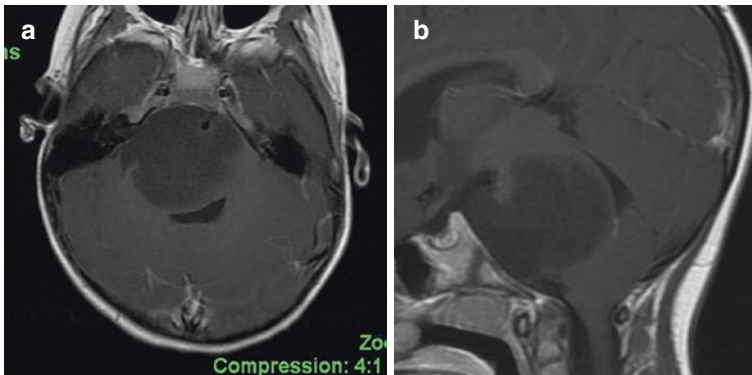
(a Axial, b sagittal) A typical DIPG in a 4½-year-old girl with a 1-week history of facial asymmetry. Note diffuse enlargement of the pons and exophytic growth surrounding the basilar artery. The tumor is hypointense on T1-weighted sequences, hyperintense on T2, FLAIR, and shows no enhancement with gadolinium
